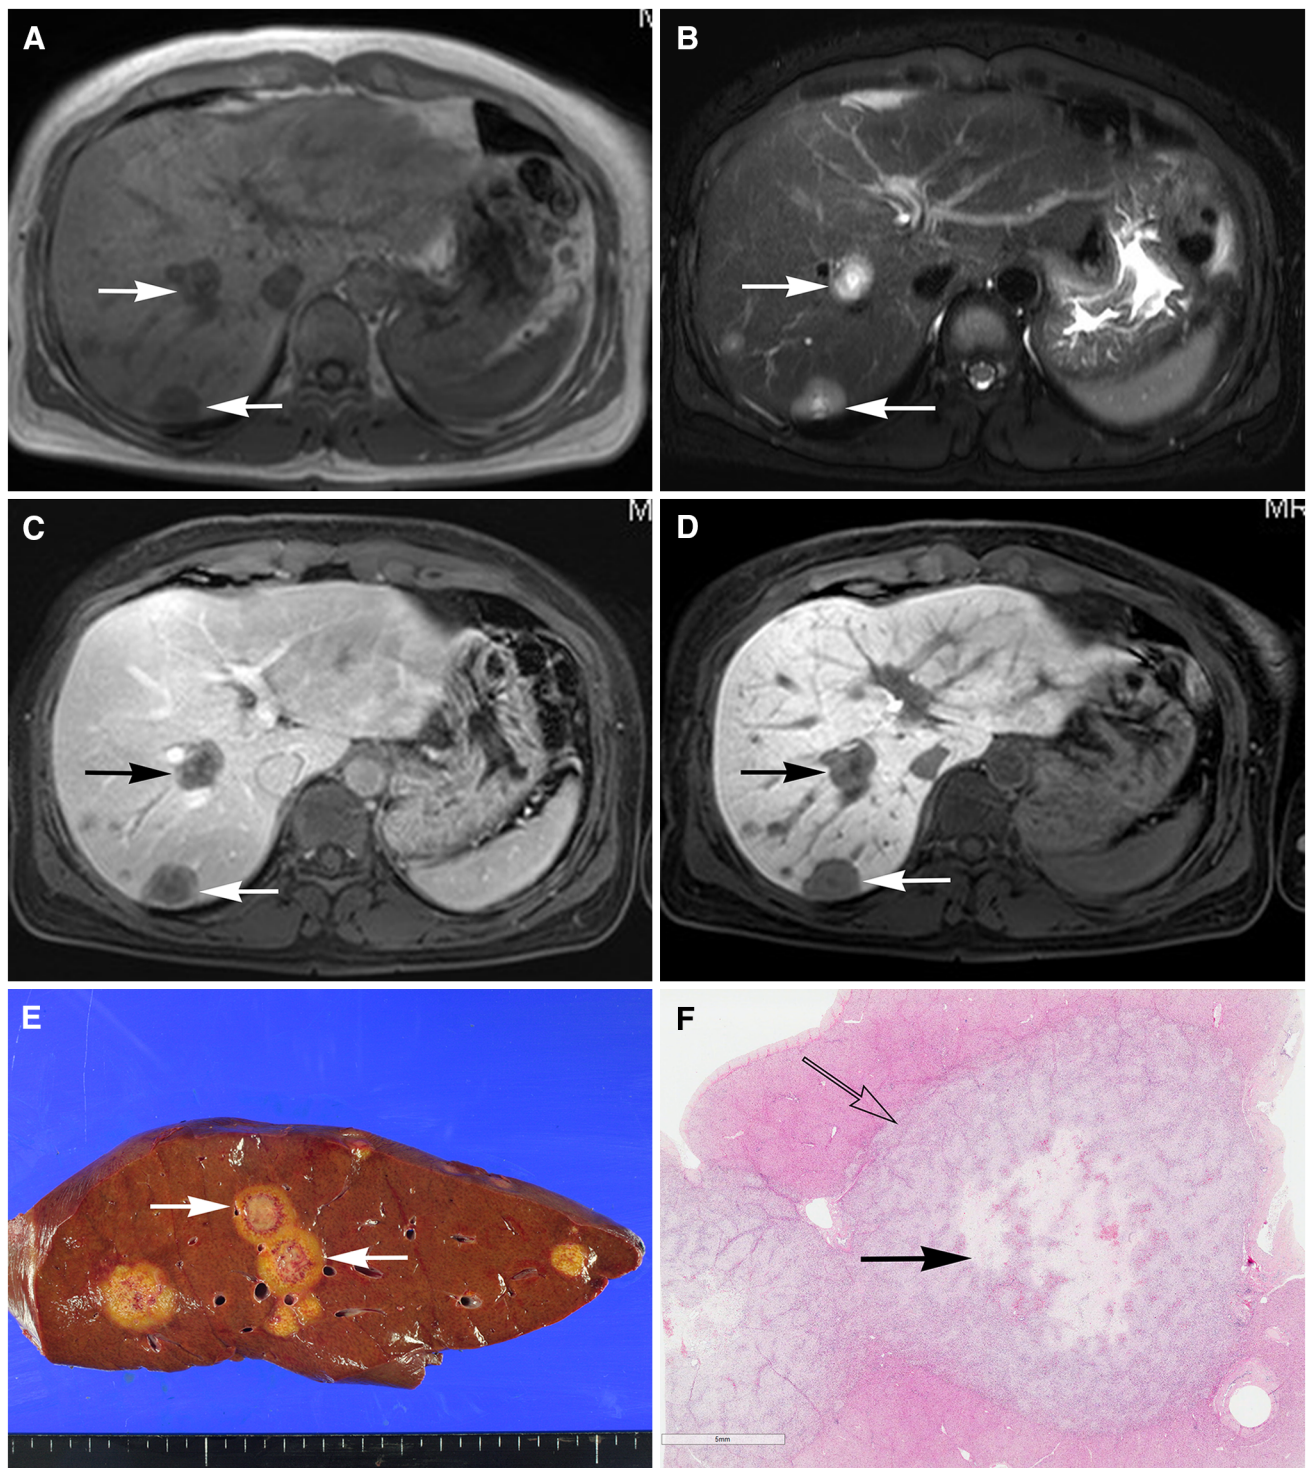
Core pattern of hepatic epithelioid hemangioendothelioma (HEH). A 44-year-old female diagnosed with multiple HEH following explantation of the liver. T1- and T2-weighted images, respectively, show multiple round hypo- and hyperintense masses (*arrows*) that are coalescent (A, B). Portal venous phase image after administration of Gd-EOB-DTPA C shows that the signal intensity of the central portion
